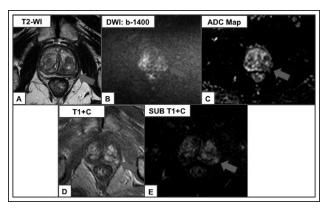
Axial T2WI image (A) demonstrates a hypointense lesion in the posterolateral peripheral zone of left mid gland (arrow), DWI b-value 1400 (B) demonstrates equivocal hyperintense signal corresponding to the findings on T2WI, ADC map (C) demonstrates questionable mildly hypointense signal equivocal for mild diffusion restriction, dynamic contrast-enhanced image (D) demonstrates early avid arterial hyperenhancement, subtracted image of the DCE (E) demonstrates avid arterial hyperenhancement. The findings from T2WI and DWI are in keeping with a PIRADS 3 lesion. It is upgraded to PIRADS 4 due to the findings on the DCE.
